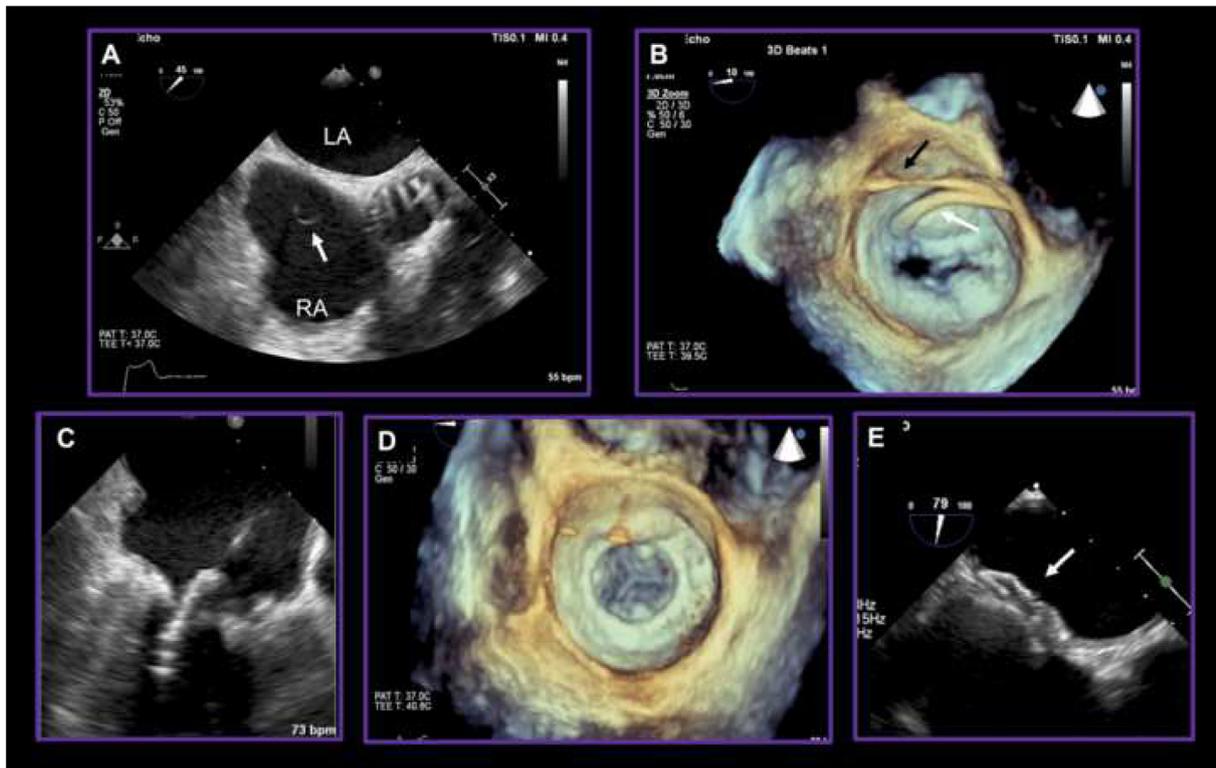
A. Transesophageal (TEE) imaging demonstrating thrombus (white arrow) in right atrium (RA). B. 3D TEE reconstruction imaging demonstrating mitral stenosis with Agilis sheath directed from transeptal position to left atrium across mitral valve (white arrow). The Amplatz wire is seen in the Pulmonary vein (black arrow). C. TEE demonstrating positioning of TMVR prosthesis in mitral annular calcification (MAC). D. 3D TEE imaging of deployed TMVR. E. TEE imaging of successfully deployed Figulla Flex II device to close iatrogenic ASD (white arrow).
